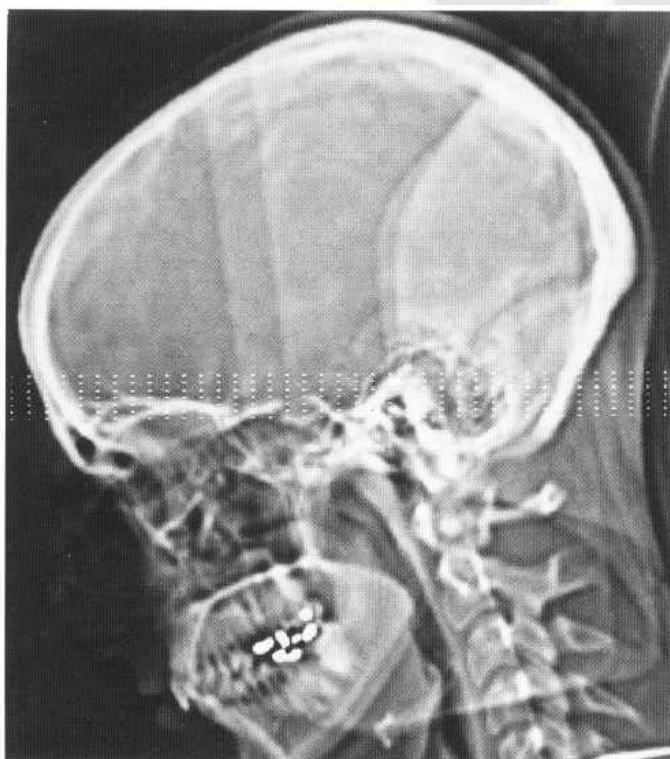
The sections for a routine axial CT examination of the temporal bone shown on a sagittal scout view.
